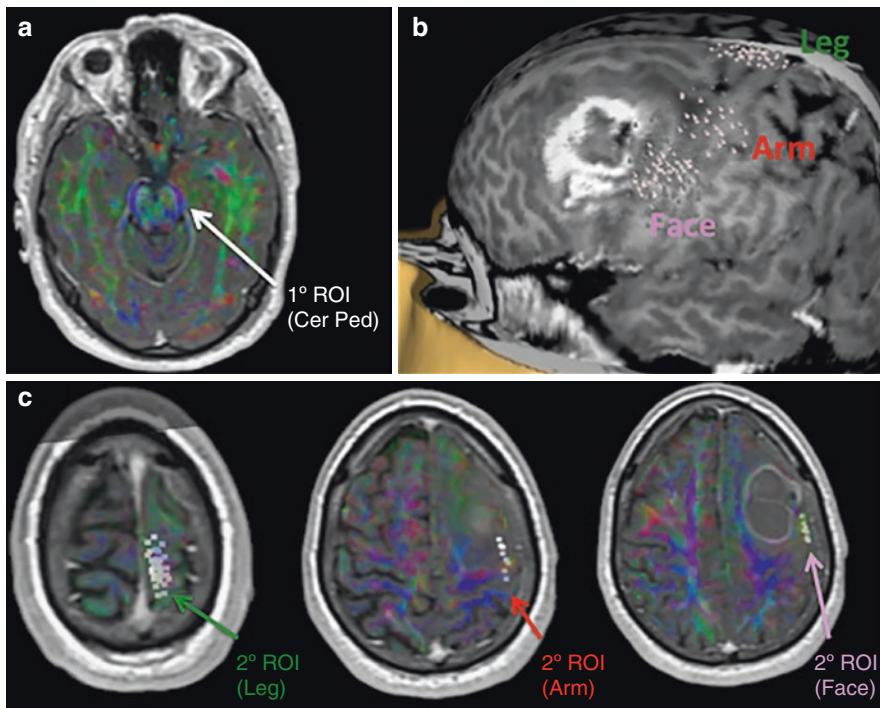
nTMS-based DTI FT of the CST in the case of a left frontal glioblastoma. (a) The DEC map was coregistered with a reference MRI scan to select the first ROI corresponding to the anterolateral portion of the cerebral peduncle; (b) the somatotopic nTMS map of the motor cortex is divided into three ROIs, each corresponding to the cortical representation of leg, arm, and face muscles; (c) the three nTMS-based functional areas are separately used as second ROIs to compute three different components of the CST
